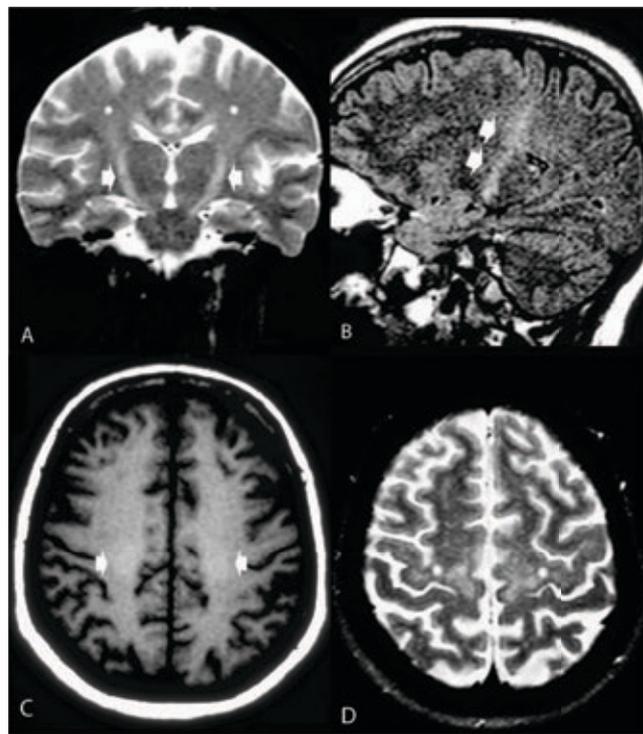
Conventional MRI in ALS (44-year-old woman). (A) Coronal T2WI depicts hyperintensity along the supratentorial CST (arrows). Note a faint hyperintensity in the subcortical regions (white spots). (B) Sagittal FLAIR image shows a similar abnormality from the subcortical region to the internal capsule. (C) Axial T1WI shows spontaneous hyperintensity in the CST in the centrum semiovale in this patient with spastic paraparesis (arrows). (D) Axial T2WI shows obvious hyperintensity in the subcortical precentral regions (white spots). Note a thin "motor dark line", mainly in the motor area for the hands. All of these abnormalities are seldom in the MRI of ALS patients, and to variable degrees, they can be identified in healthy individuals.
